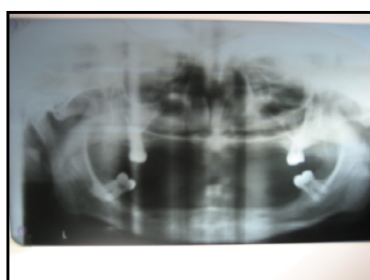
Orthopantomograph showing severe bone loss.
